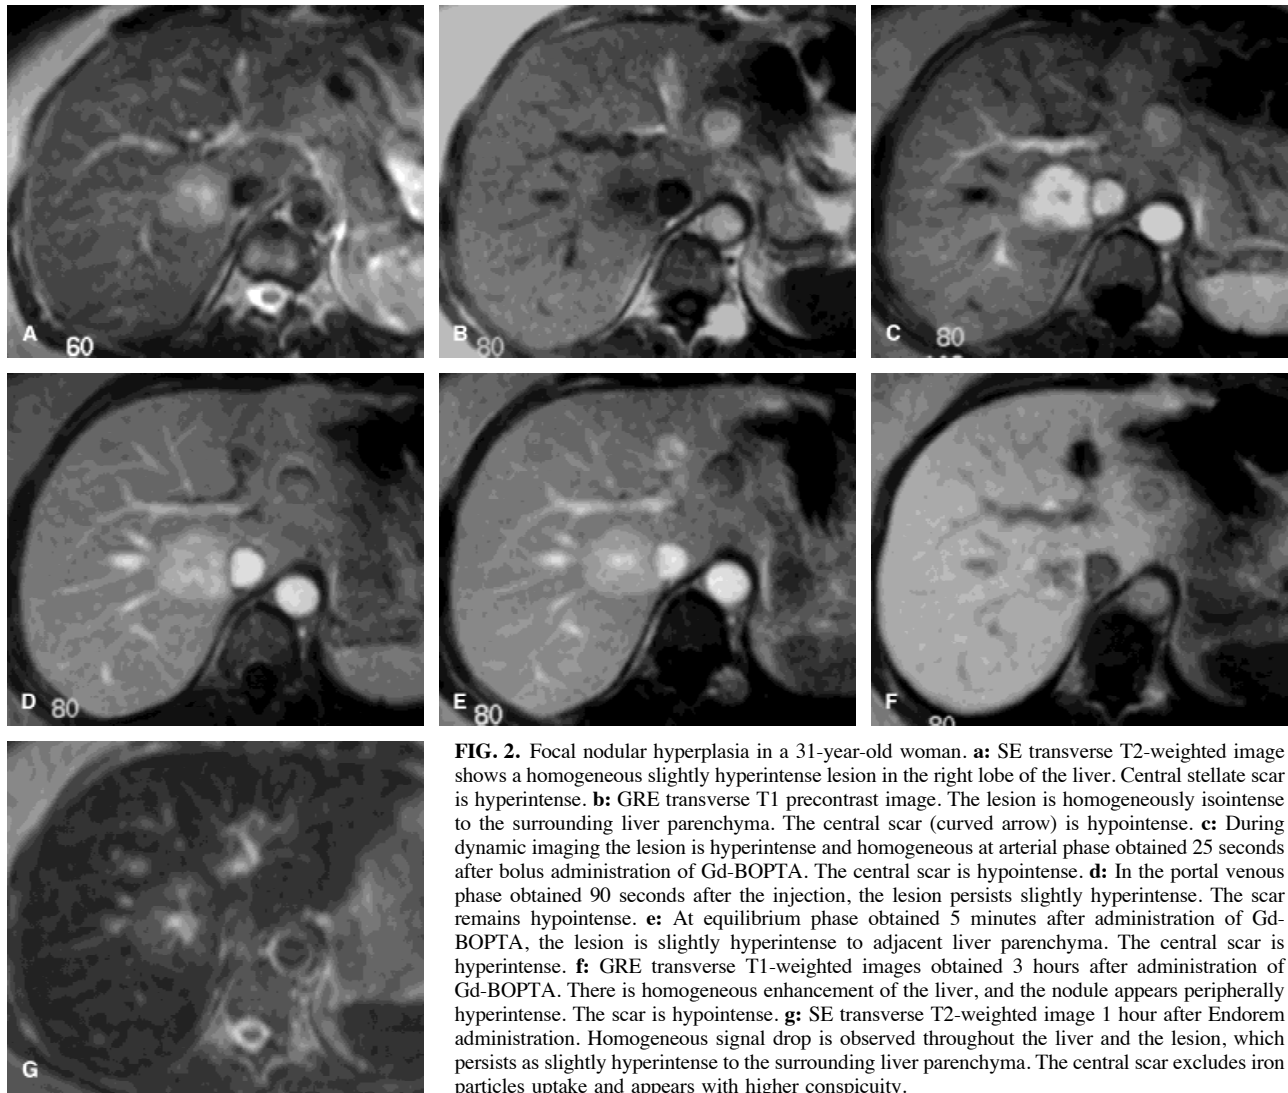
Focal nodular hyperplasia in a 31-year-old woman. a: SE transverse T2-weighted image shows a homogeneous slightly hyperintense lesion in the right lobe of the liver. Central stellate scar is hyperintense. b: GRE transverse T1 precontrast image. The lesion is homogeneously isointense to the surrounding liver parenchyma. The central scar (curved arrow) is hypointense. c: During dynamic imaging the lesion is hyperintense and homogeneous at arterial phase obtained 25 seconds after bolus administration of Gd-BOPTA. The central scar is hypointense. d: In the portal venous phase obtained 90 seconds after the injection, the lesion persists slightly hyperintense. The scar remains hypointense. e: At equilibrium phase obtained 5 minutes after administration of Gd-BOPTA, the lesion is slightly hyperintense to adjacent liver parenchyma. The central scar is hyperintense. f: GRE transverse T1-weighted images obtained 3 hours after administration of Gd-BOPTA. There is homogeneous enhancement of the liver, and the nodule appears peripherally hyperintense. The scar is hypointense. g: SE transverse T2-weighted image 1 hour after Endorem administration. Homogeneous signal drop is observed throughout the liver and the lesion, which persists as slightly hyperintense to the surrounding liver parenchyma. The central scar excludes iron particles uptake and appears with higher conspicuity.
